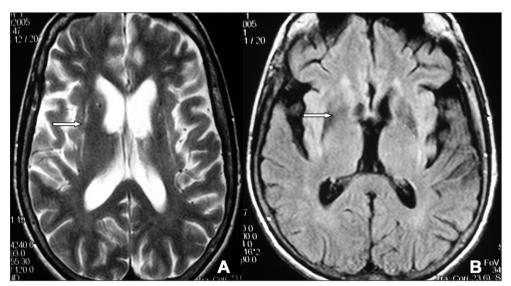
Case 2. MRI: (A) Marginal hyper intensity in T2 image (arrow). (B) Putaminal hypo intensity in T1 image (arrow).
